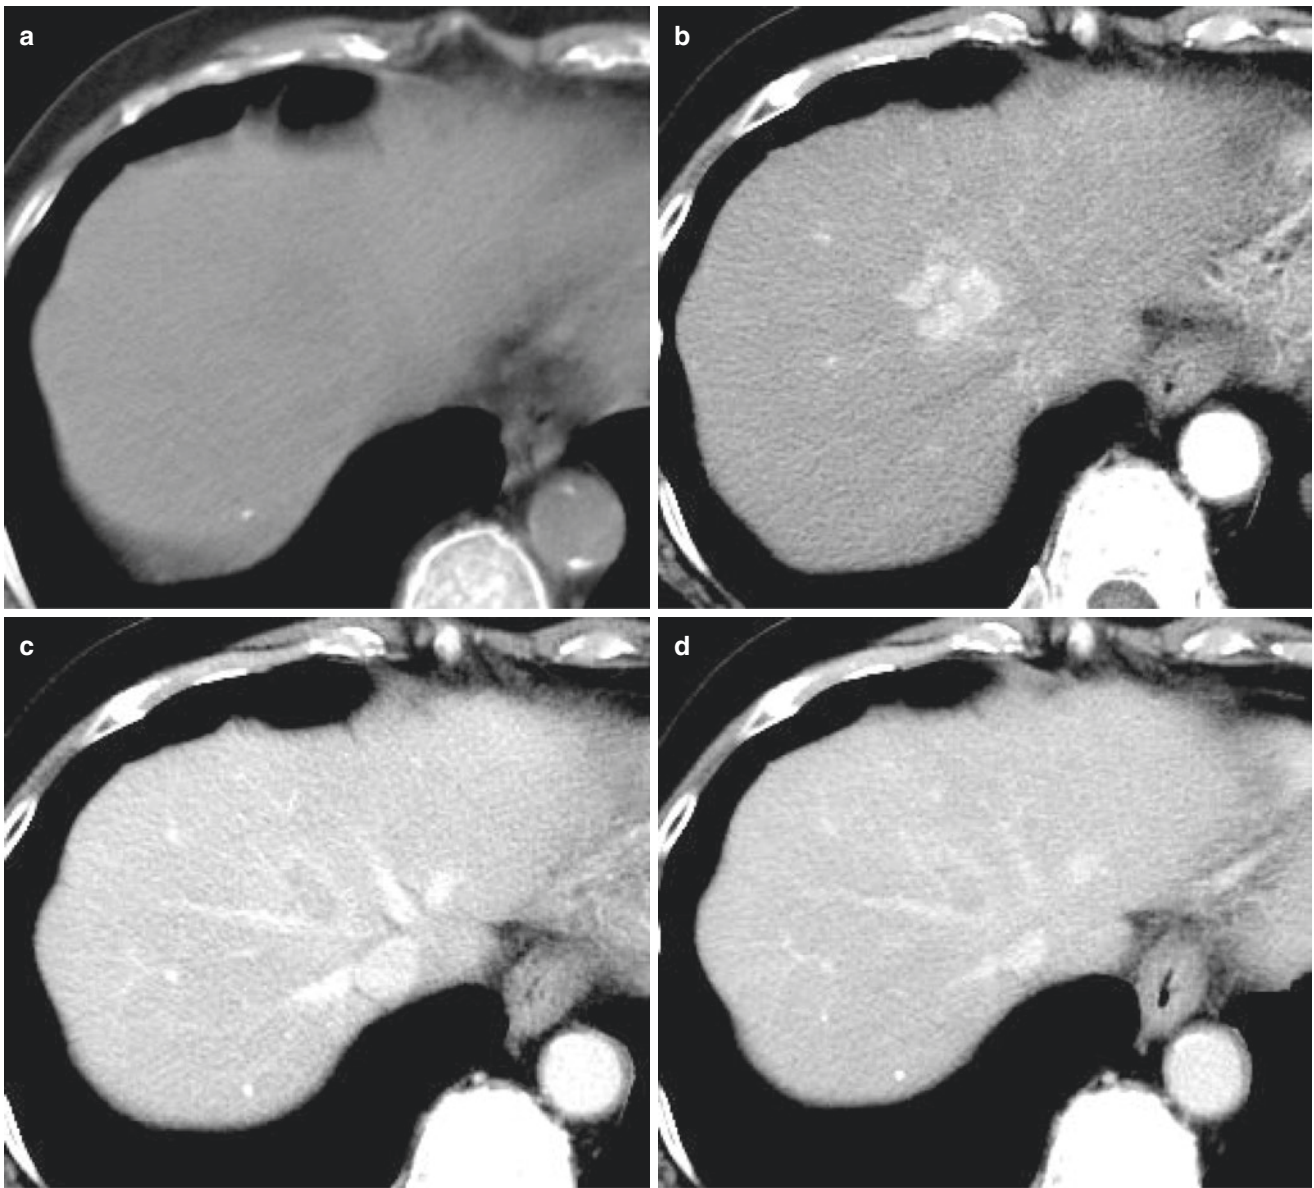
Cholangiocellular carcinoma with the component of cholangiolocellular carcinoma; CT images of the tumor. Plain CT image (a), arterial-phase image (b), portal-venous-phase image (c), and equilibrium-phase image (d) are shown. The nodule showed slightly
